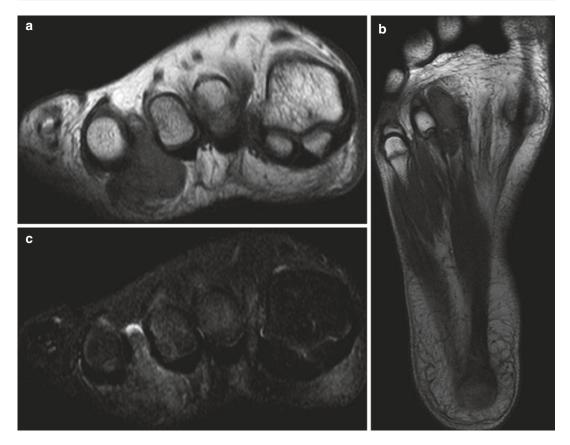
(a–c) Diffuse giant cell tumour of the foot. (a) Short-axis and (b) long-axis T1-weighted MR images. (c) Short-axis STIR MR image. There is a subcutaneous, extra-articular, lobulated mass, which is of intermediate SI relative to skeletal muscle on T1-weighted images with a few foci of low signal in keeping with haemosiderin deposits (a, b). These are more conspicuous on gradient
